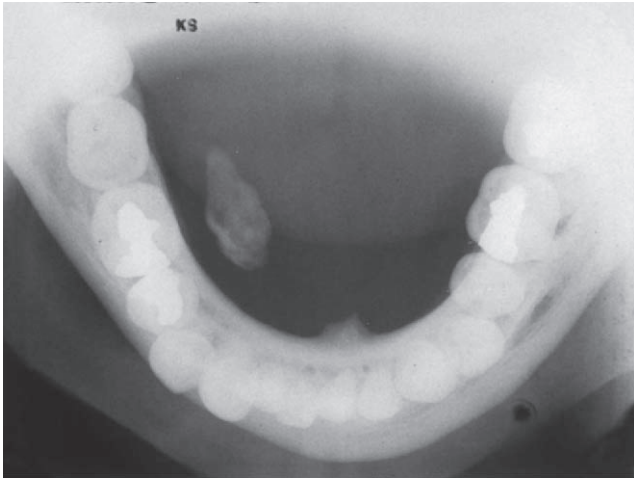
A mandibular occlusal radiograph showing a sialolith in the patient's right submandibular gland duct.
